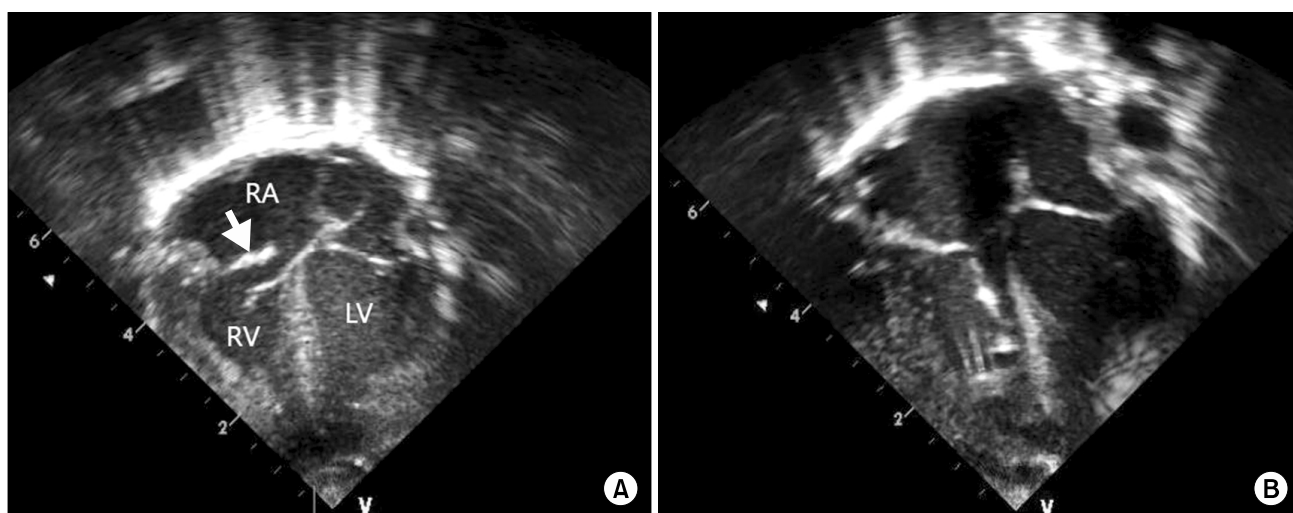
(A) Preoperative transthoracic echocardiogram showing a flail anterior leaflet of the tricuspid valve with a thickened echogenic tip prolapsing into the right atrium (arrow). (B) Postoperative transthoracic echocardiogram showing the artificial cord supporting the leaflet and the restoration of adequate coaptation. RA, right atrium; RV, right ventricle; LV, left ventricle.
